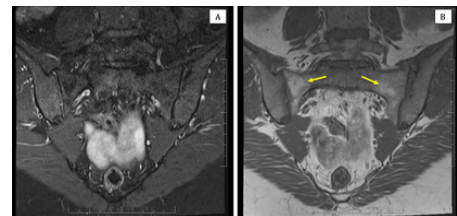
MRI sacroiliac oblique coronal STIR (A)/T1 (B) sequences (February 2024): There is no evidence of active sacroiliitis, no bone marrow edema identified. There are regions of fatty metaplasia in the sacral area (yellow arrows) that is likely physiological.
